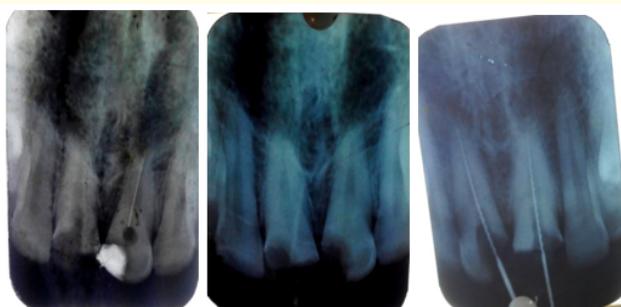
Initial Radiograph after removal of instrument w/l m X-ray.
